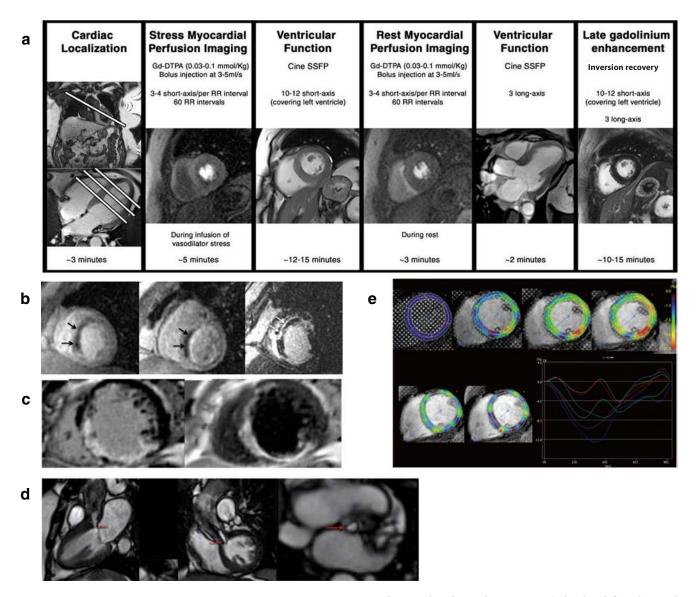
Cardiac MRI. a Acquisition protocol includes assessment at rest and during vasodilator stress. (Reproduced from Coelho-Filho et al. [64]). b Short-axis perfusion MRI showing mid-anteroseptal and anterior wall motion abnormality, rest (left) and stress (middle) perfusion abnormality (black arrows), and myocardial delayed enhancement (right, white arrows) consistent with infarct. (Adapted from Jenson et al. [65]). c Bright-blood and dark-blood late gadolinium enhancement reveals contrast between the subendocardial scar and adjacent blood pool. (Adapted from Francis et al. [66]). d Subvalvular obstruction (red arrows) secondary to subaortic membrane seen on 3-chamber (left) and coronal (right) views. (Reprinted from Cavalcante et al. [67]). e Color-coded strain map of tagged MRI shows heterogeneous strain values in the left ventricle throughout one cardiac cycle (left upper: first frame at enddiastole; right upper: end-systole; lower row: diastole). The time-strain curves of six myocardial segments show variations in the peak time of each strain curve; left ventricular dyssynchrony is identified (right lower). (Figure reproduced from Nagao and Yamasaki [68]) Using cardiac MRI, myocardial viability is assessed via spatial distribution of intravenously injected contrast agents. The same injection also provides information on the perfusion status of heart muscle. Table 1 summarizes the role of various imaging modalities in the diagnosis of HFpEF. Table 2 highlights imaging modalities that are useful for assessing various physical or functional parameters relevant to HFpEF.
